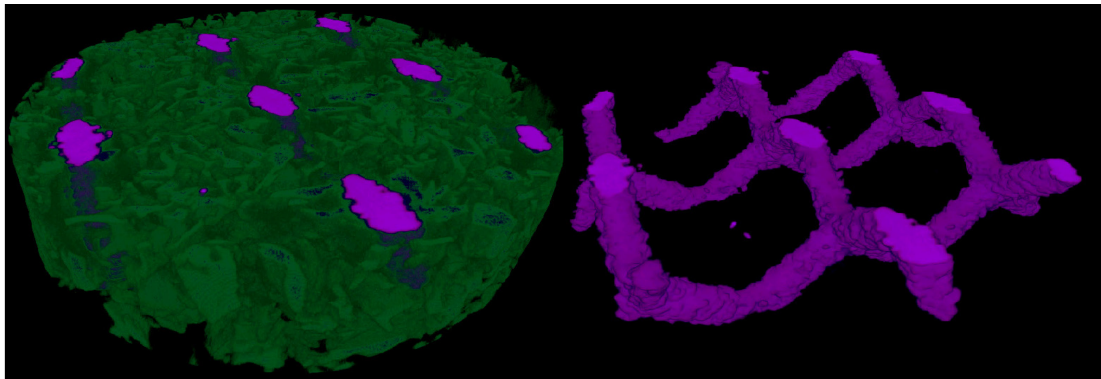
μ CT image of titanium-bone sample. Titanium is purple and bone green.
